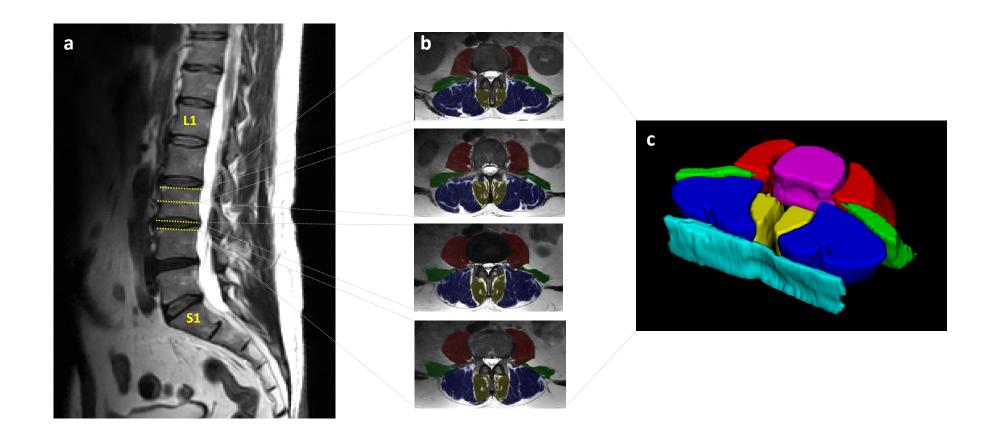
Sagittal (a) and selective axial MRI images (b) of the spine showing the ROI for the psoas (red), quadratus lumborum (green), erector spinae (blue) and multifidus (yellow) muscles at the superior endplate L3, mid-vertebral slice L3, intervertebral disc L3/L4 and superior endplate L4. 3-D rendering of the axial image segmentations (c) is show with additional region of subcutaneous back fat (turquoise) and vertebral column (pink) for visualisation.
